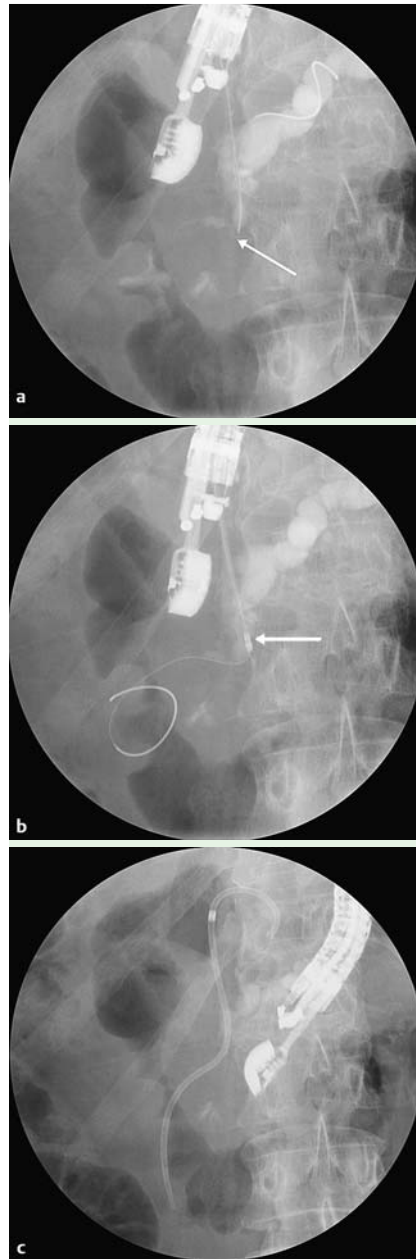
a Endoscopic ultrasound (EUS)-guided antegrade opacification with complete stop (arrow) in head of the pancreas. b EUS and fluoroscopy-guided antegrade recanalization with 6-Fr cystogastrostome (arrow indicates the tip) through the duct of Santorini, minor papilla, and the duodenum. c EUS-guided antegrade placement of a pigtail 7-Fr pancreatic stent.
